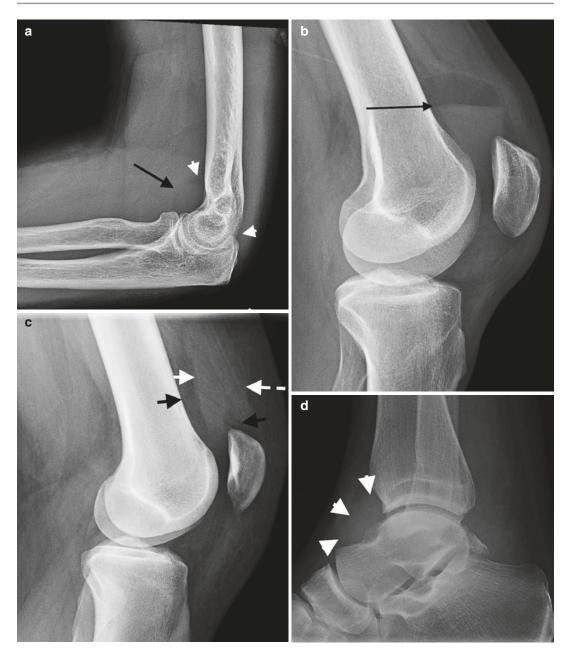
Joint effusions: (a) lateral elbow radiograph with moderate effusion (*black arrow*) and sail sign, displacing the anterior fat pad superiorly, and the posterior fat fad becomes visible (*arrowheads*). (b) Lateral standing knee radiograph with fat fluid level (*arrow*) in keeping with lipohemarthrosis in patient with lateral tibial plateau
